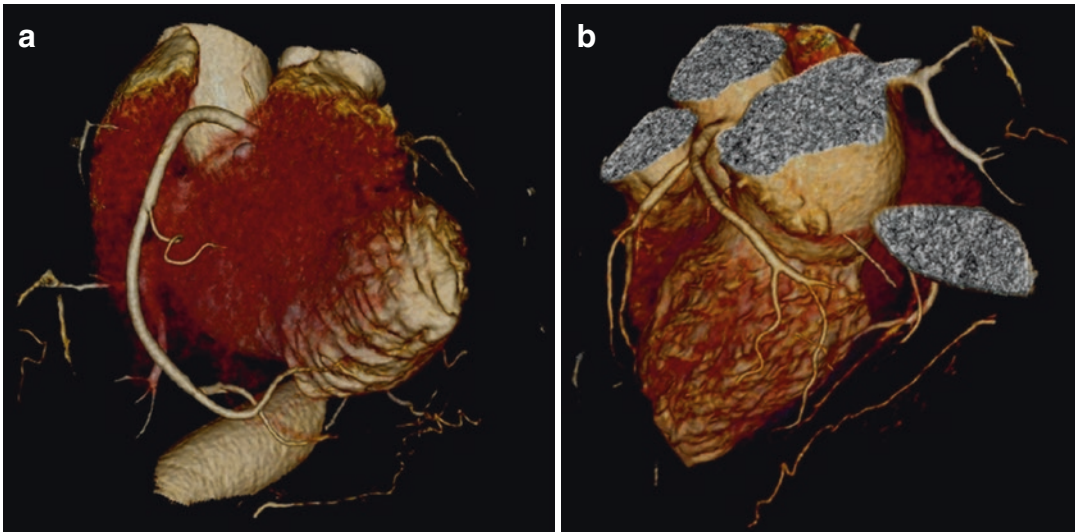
Normal coronary arteries on coronary CT angiography. 3D volume rendering CT angiographic images demonstrate the normal right coronary artery (a) and left coronary artery (b)
